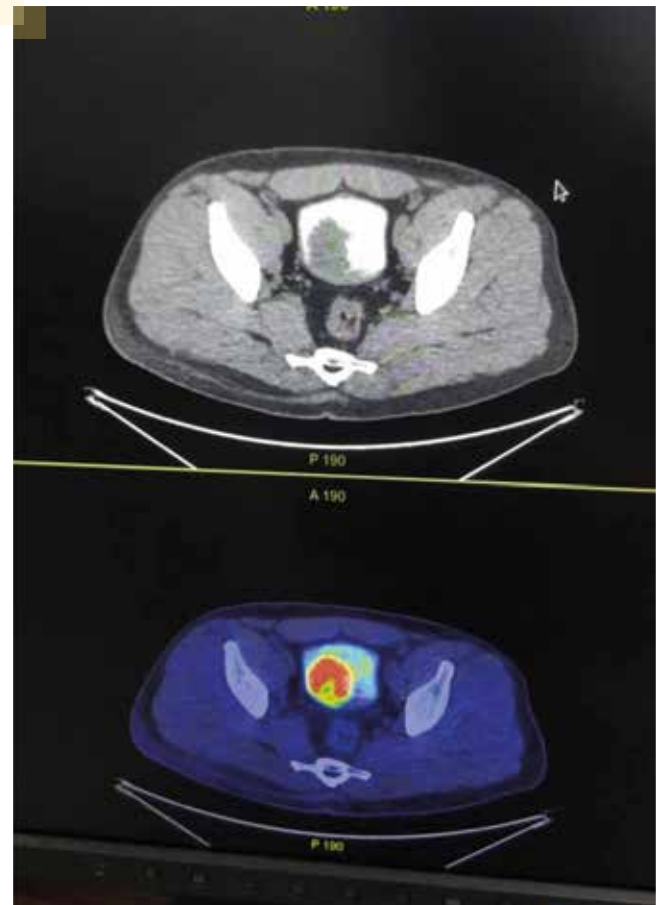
PET CT revealing the FDG avid Growth on the bladder
